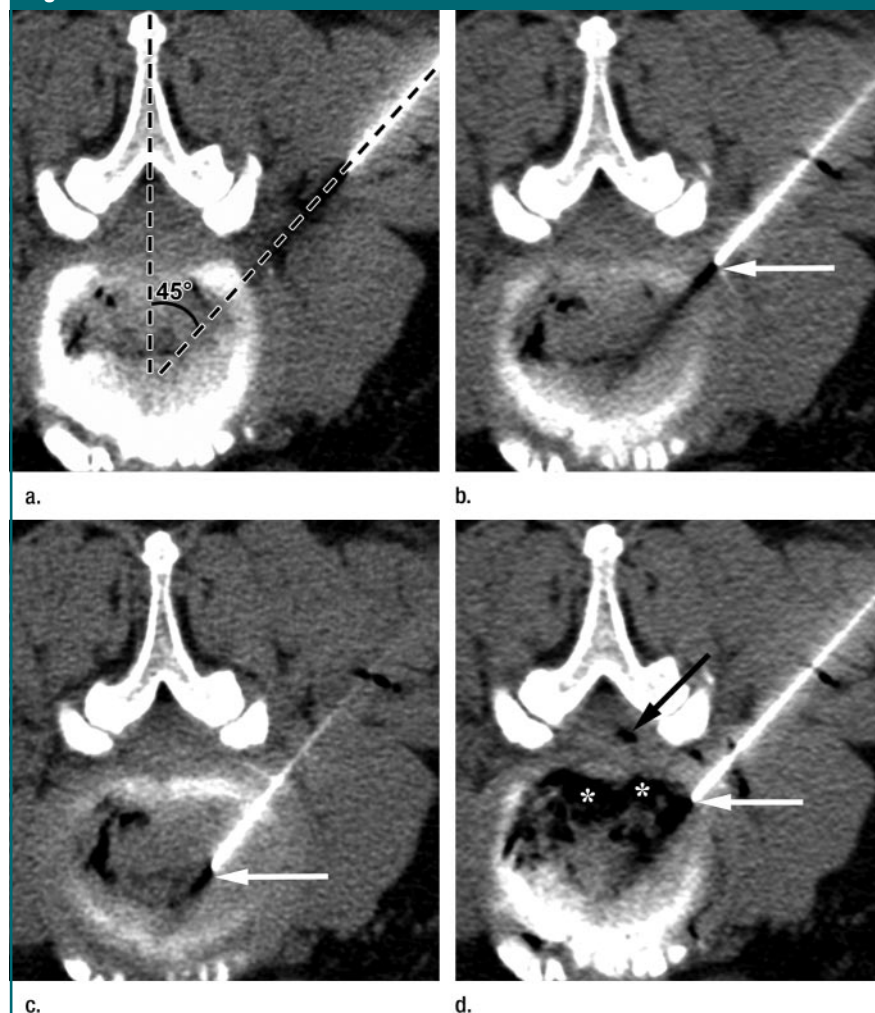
Transverse CT images of consecutive phases of $\text{O}_2\text{-O}_3$ chemodiscolysis with right paravertebral approach at L4-5 level in 65-year-old man in prone position. (a) Entry path with a 45° angle. (b) Tip of the needle (arrow) is in periradicular position. (c) Needle is advanced inside the disk following the same path; the position is confirmed by evidence of needle tip (arrow). (d) Distribution of gas after intradiscal and periradicular injections; the needle is still on site (white arrow). The $\text{O}_2\text{-O}_3$ mixture is distributed inside the disk (*) and in epidural space (black arrow).
